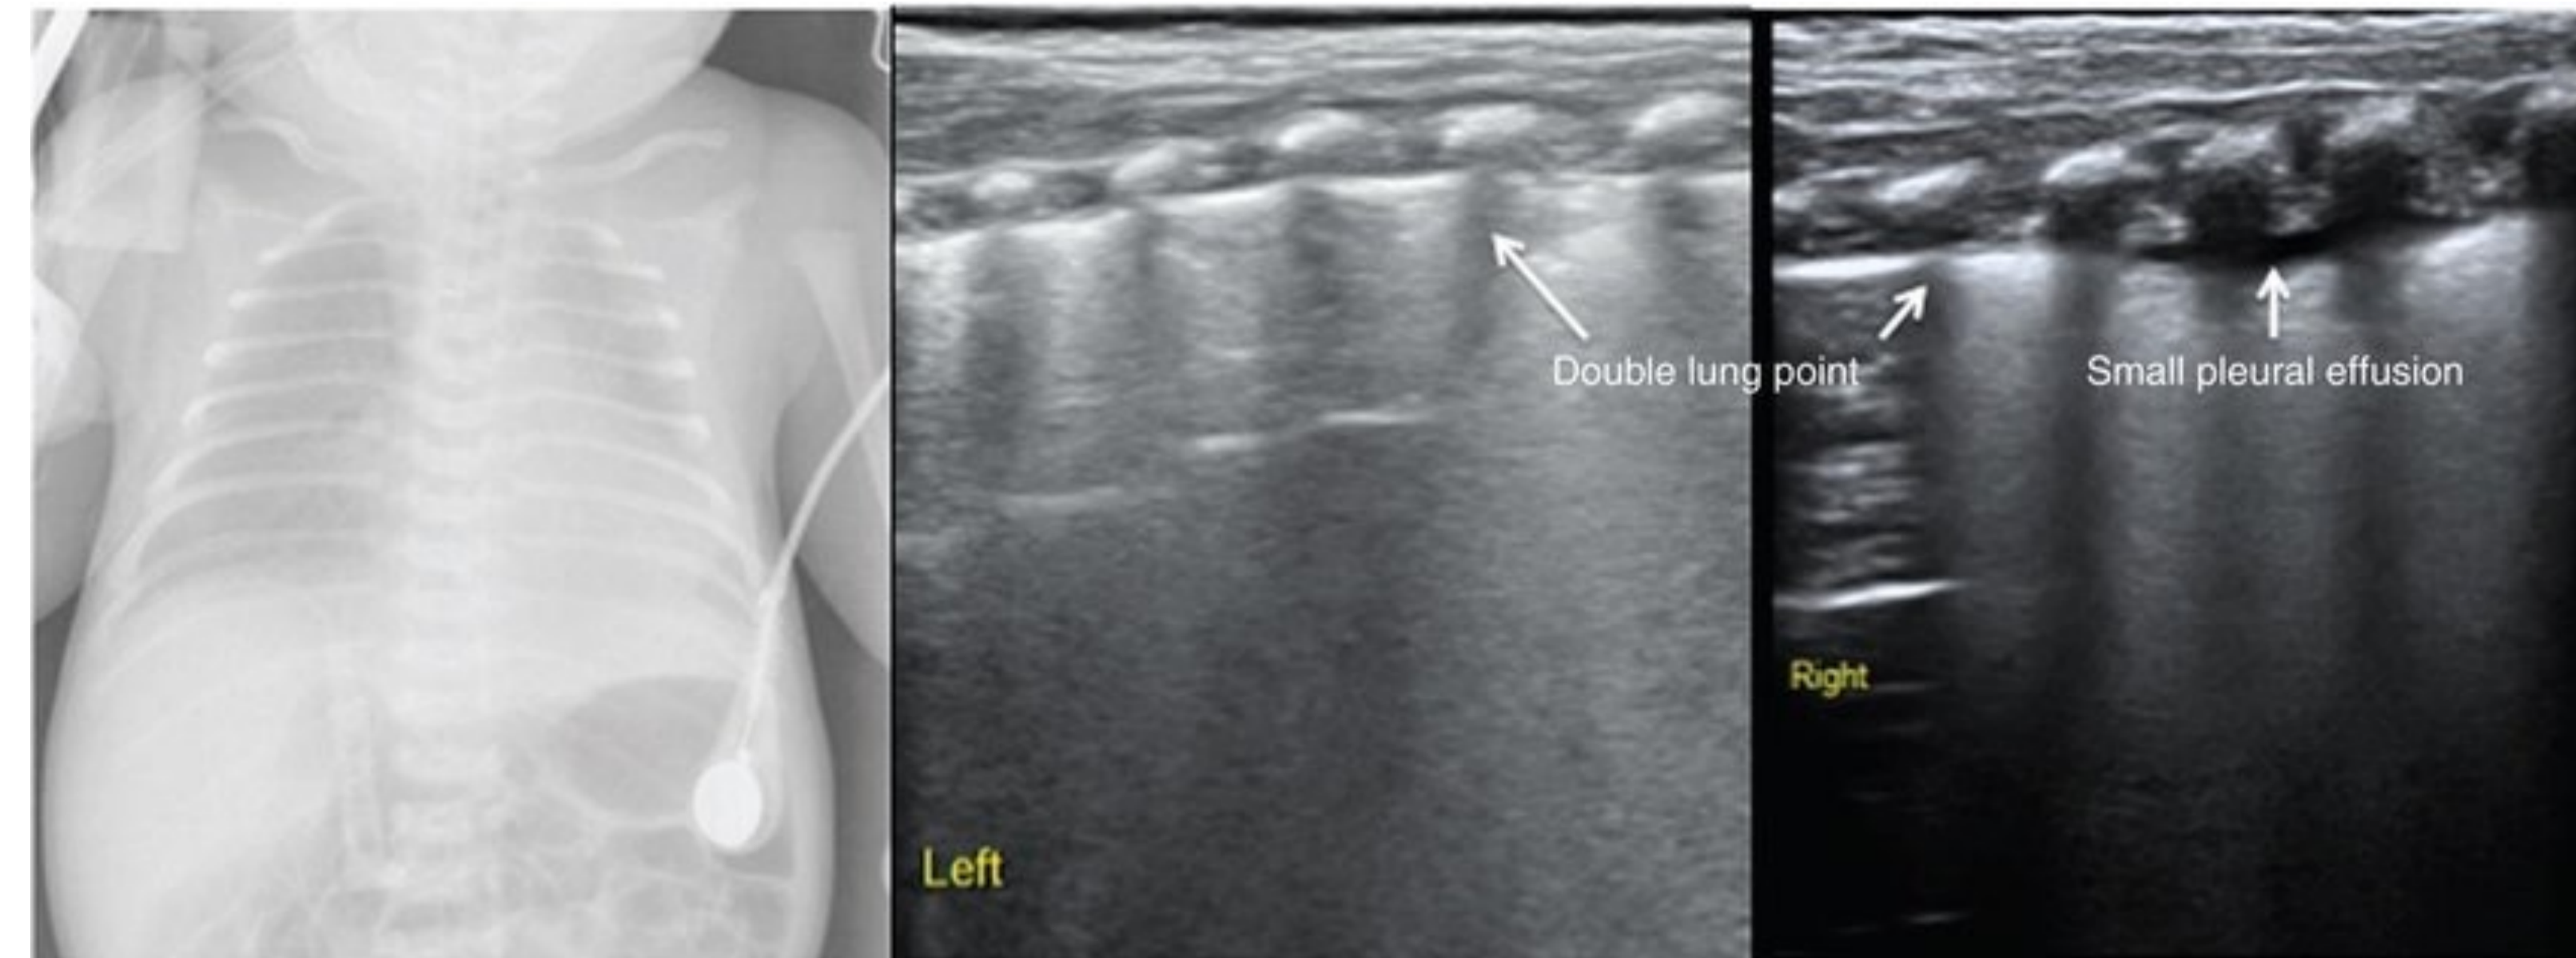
Differentiation between TTN and RDS. Infant was 38 weeks and delivered via cesarian section. Developed progressive dyspnea after birth and was diagnosed with RDS based on clinical and CXR manifestations. However, lung ultrasound showed A line disappearance with no lung consolidation. Confirming TTN as well as the presence of the double lung point, the infant did not require any respiratory interventions 24 hours post delivery consistent with the clinical pathway of TTN⁸.
